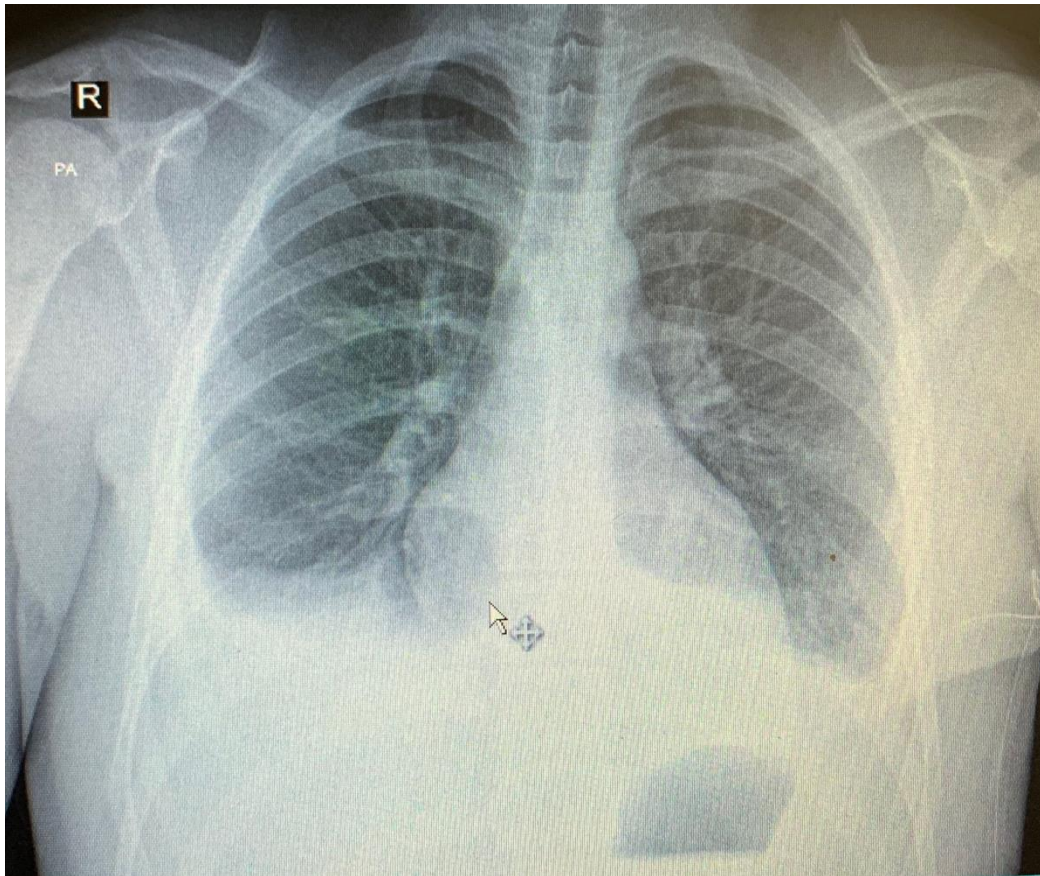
Case 3, chest X-ray after pleural puncture on the right side due to pleural effusion, third postoperative day
